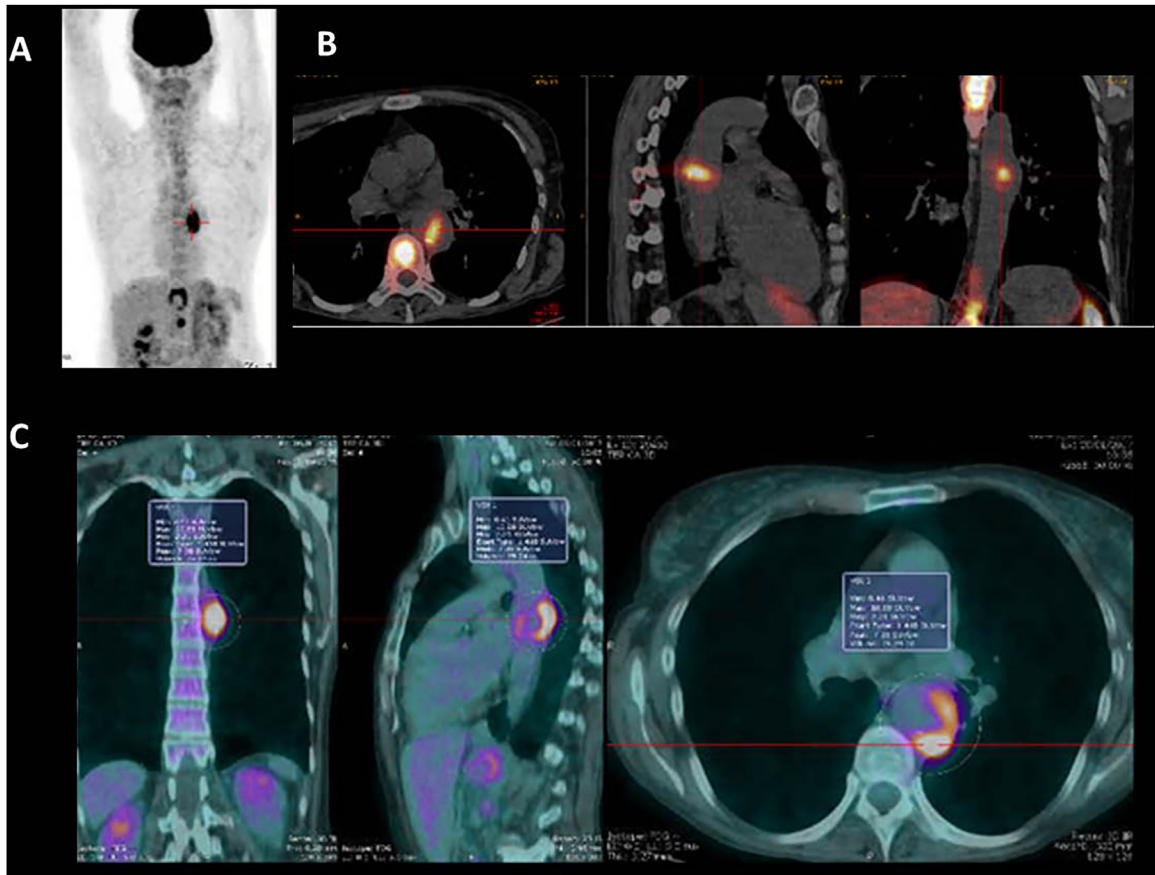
Nuclear medicine images of the descending thoracic aorta. A. Fluorinated Desoxyglucose Scintigraphy has shown a paravertebral hypermetabolic activity. B. Positron Emission Tomography using Fluorinated Desoxyglucose (FDG-PET) showing the origin of this hyperactivity located on aneurysm of the descending thoracic aorta. C. Activity has shown on aneurysm of the descending thoracic aorta with Labelled Leucocyte Scintigraphy (LLS) in agreement with FDG-PET, suggestive of a septic process in the thoracic aorta aneurysm with adjacent infiltration.
